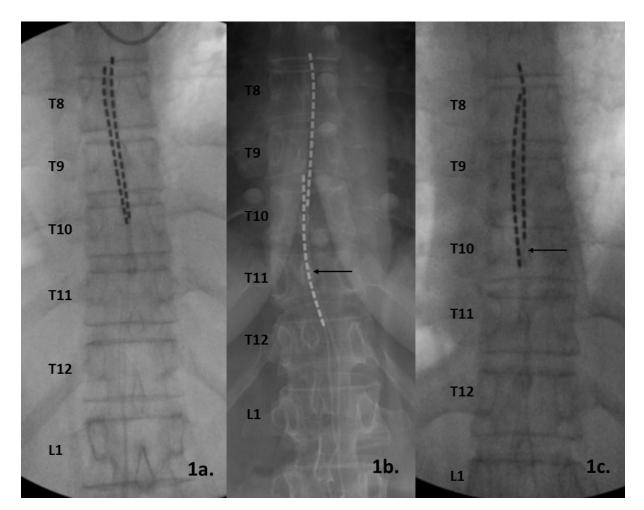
Anteroposterior radiographs of 1a) initial intraoperative imaging demonstrating successful lead placement spanning T8 and T9 vertebrae, 1b) diagnostic imaging demonstrating significant right lead caudal migration to T10 and T11 vertebrae, and 1c) post revision operative imaging demonstrating successful replacement of the right lead.
